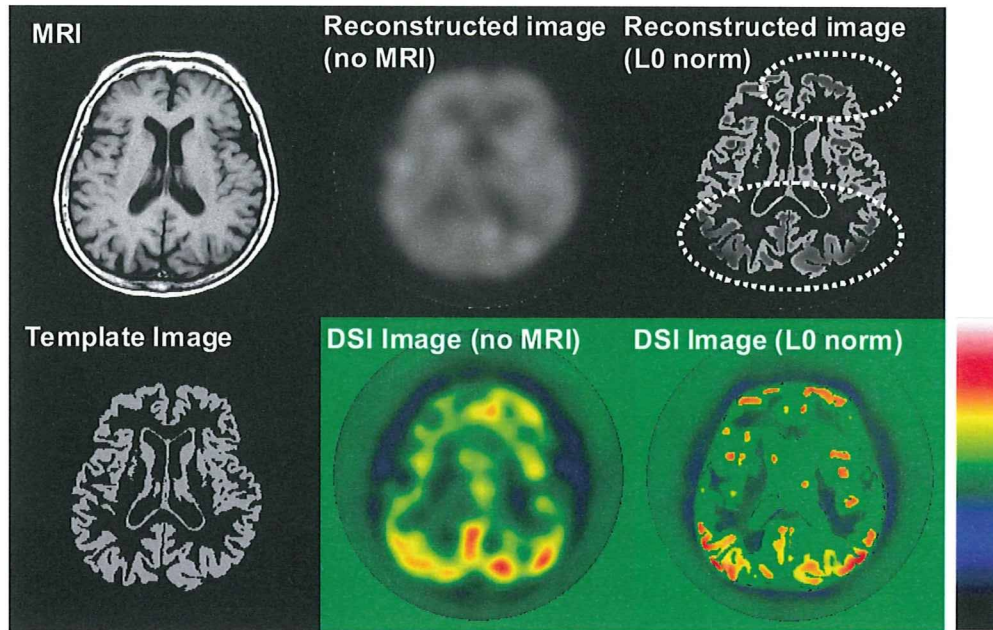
Reconstructed images and DSI images obtained from SPECT projection data for a case of Alzheimer's disease.
